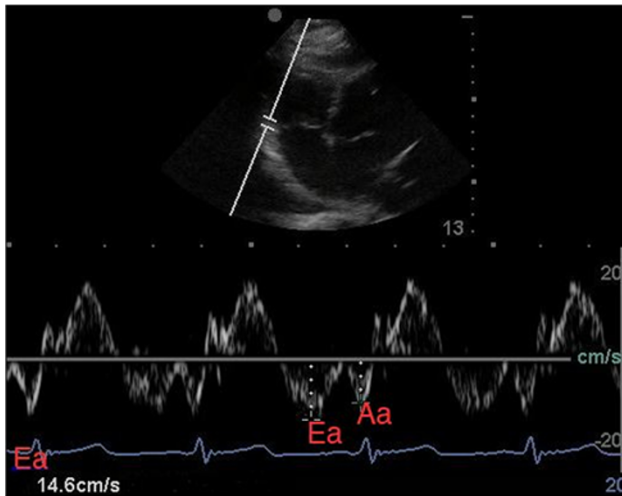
Apical 4 chamber view: tissue doppler early diastolic E_a wave-lateral right ventricle
